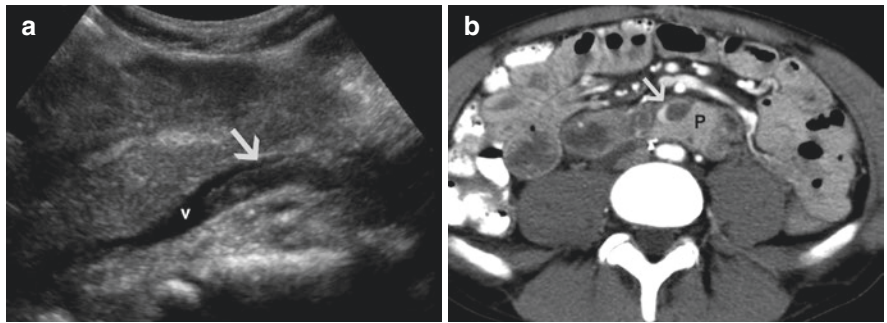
(a) Gray-scale ultrasound of the pancreas transplant shows a non-occlusive thrombus (arrow) within the transplant vein (v). (b) Axial contrast-enhanced CT of the transplant pancreas shows a non-occlusive thrombus within the graft vein
